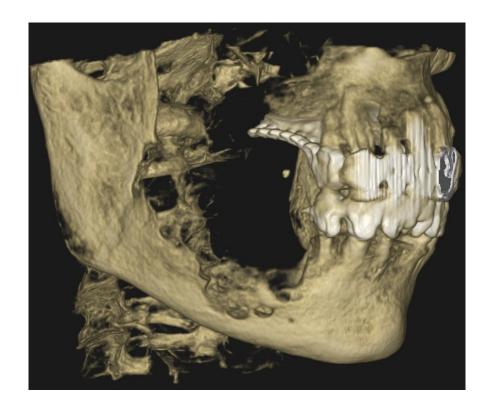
CBCT showing bone damage with this mitted bone appearance
